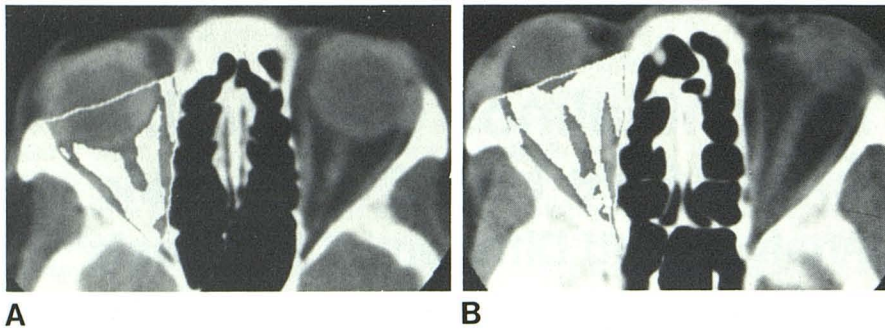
Orbital boundaries and volume measurements. A, Midorbital axial CT section, control subject. No evidence of proptosis. Volume measurements were performed on right orbit. Anterior orbital boundary is defined by white line passing through globe from zygoma to lacrimal bone. Traced line continues along edge of orbital bony margin. Patches of white within these boundaries represent pixels with density values in range of fat. White areas conform to areas filled with fat in opposite orbit. B, Slightly higher section in patient with proptosis caused by excess orbital fat. Considerably more orbital fat compared with control patient.
